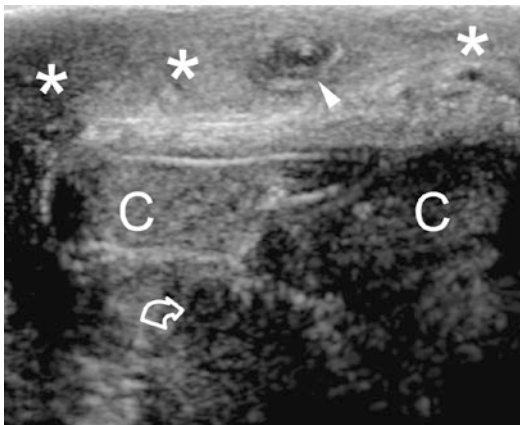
Posttraumatic thrombosis of a superficial penile vein. Axial ultrasonographic view obtained with the transducer on the dorsal aspect of the penis shows blood extravasation in the superficial tissues (*asterisks*). A noncompressible enlarged vessel with echogenic content is seen (*arrowhead*) lacking vascularization at colour Doppler interrogation. The tunica albuginea is intact. *C* corpora cavernosa. *Curved arrow* indicates the corpus spongiosum
